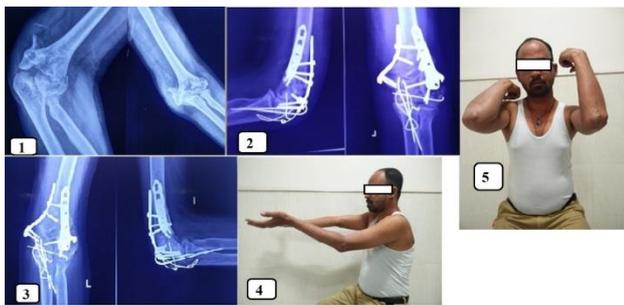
Pre-op radiographs showing distal humerus type 3C fracture in 1, immediate post-op radiograph in 2, six months follow-up radiograph showing uniting fracture in 3, six months follow-up showing elbow range of motion in 4 and 5.
